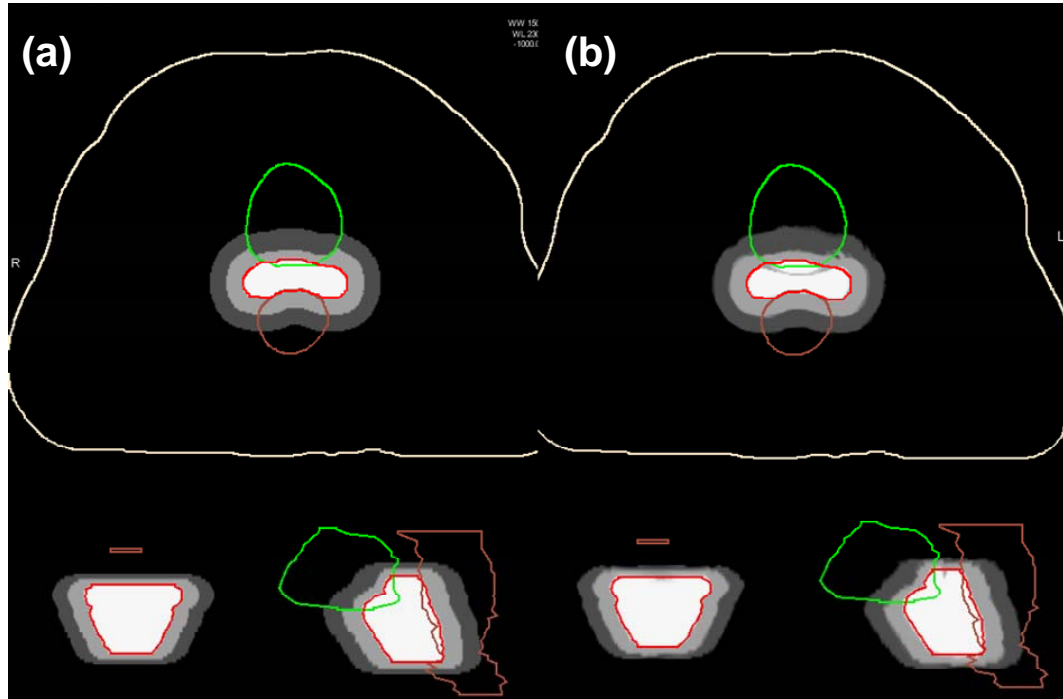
Comparison of (a) the deformed CT of the atlas case through the deformation field and (b) the CT of the query case. Images are masked for different CT numbers. High agreement is reached between two CTs indicating the accurate contour-based deformable image registration.
